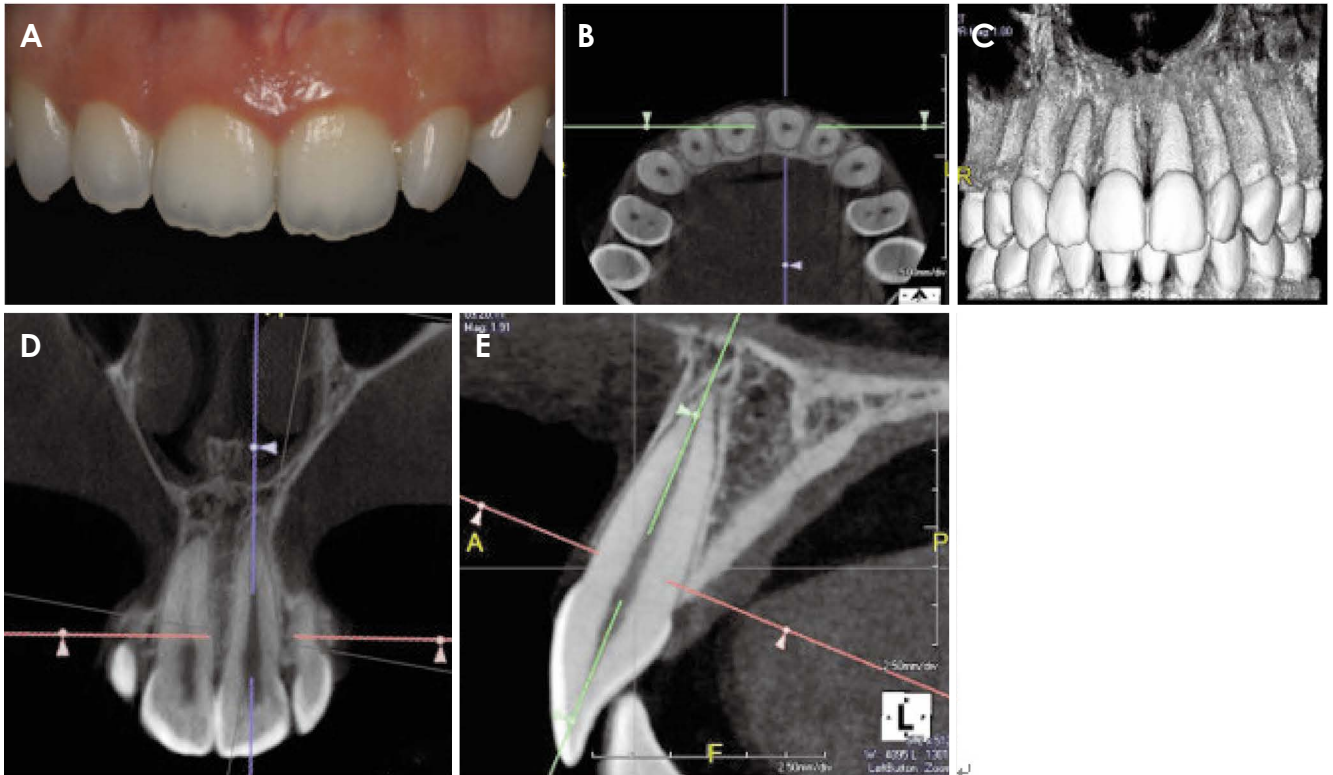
Guideline for cone-beam computed tomographic (CBCT) analysis. A. Clinical examination. B. Axial cone-beam computed tomographic (CBCT) image. C. Three-dimensional CBCT image. D. Coronal CBCT image. E. Sagittal CBCT image.
